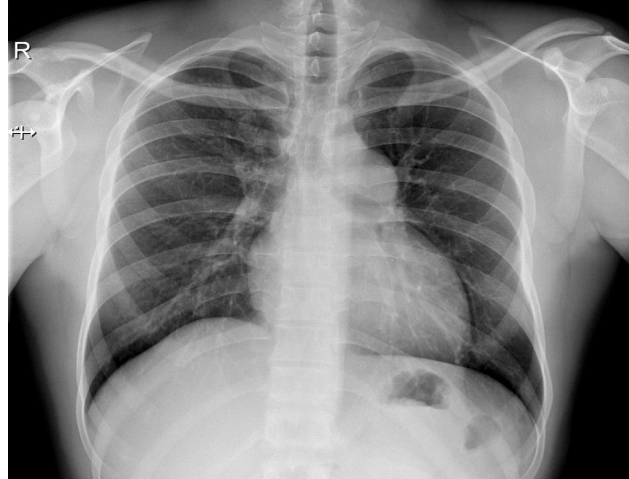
X-ray Chest PA view shows cardiomegaly, dilatation of main and left pulmonary artery. Peripheral pruning of pulmonary vasculature is conspicuously present.
